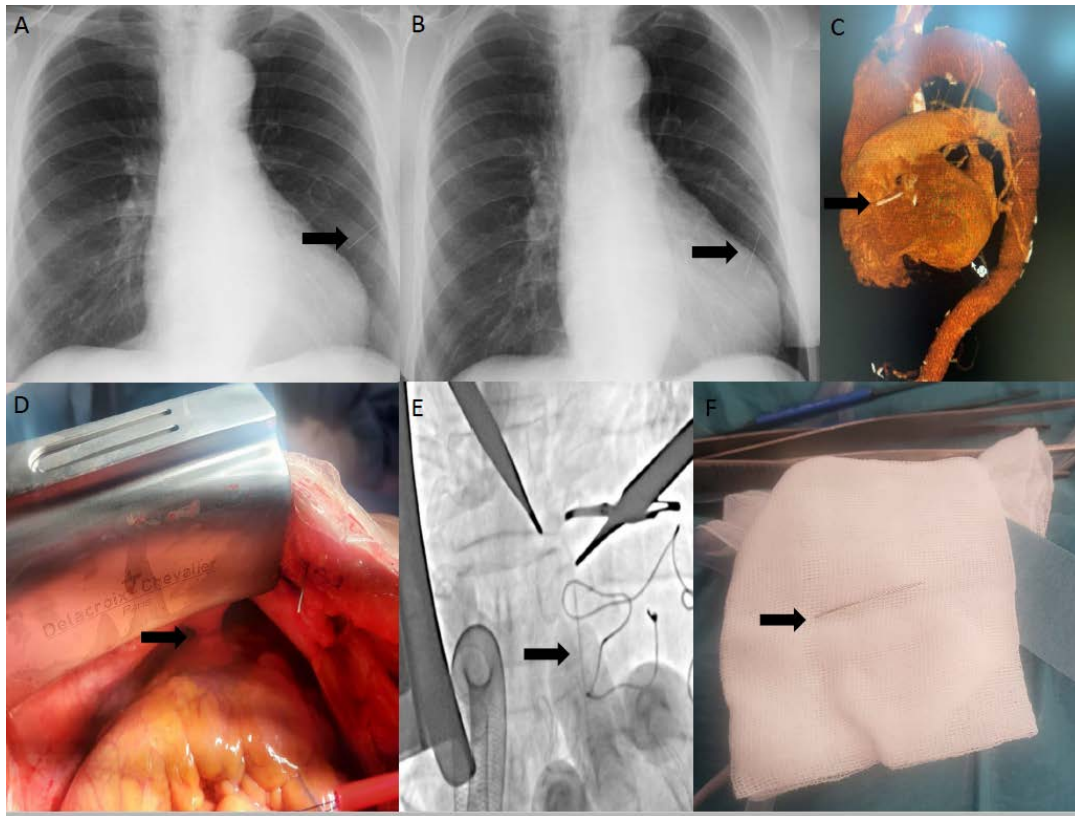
A. First chest X-ray: needle in the subcutaneous tissue. B. Second chest X-ray: needle in the pericardial sac. C. Computed tomography scan: foreign body near outflow path of the right ventricle. D. Intraoperative image: fusion in the pericardial sac. E. Live X-ray image: confirmed localization of needle. F. Needle after removed
